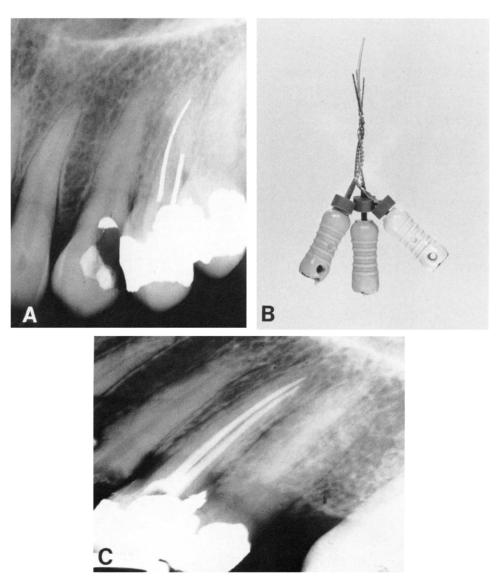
Case 4. A, Silver cones cut off well into canals. These were loosened with endosonics. B, Files braided around silver cone and withdrawn from canal. C, Postobturation radiograph.
